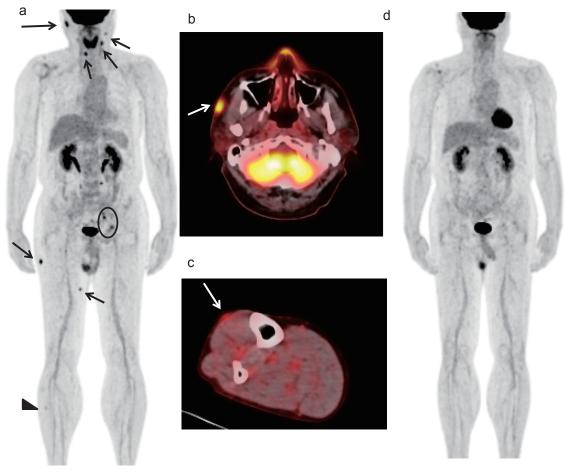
PET and PET-CT images
